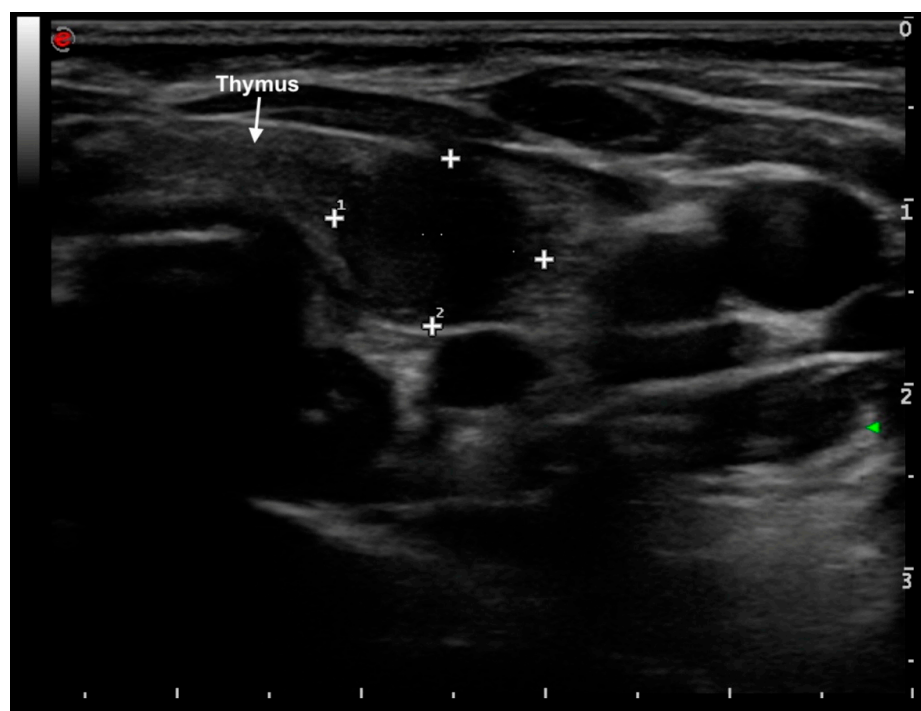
Transverse high-frequency linear ultrasound scan at the left jugular region showing a hypoechoic oval lesion (11.6 \times 9.1 mm) located within the thymic parenchyma, medial to the internal jugular vein and anterior to the carotid artery. The arrow indicates the thymus; crosses (+) mark the margins of the lesion used for measurement; the numbers (1, 2) correspond to the orthogonal diameters of the lesion.
